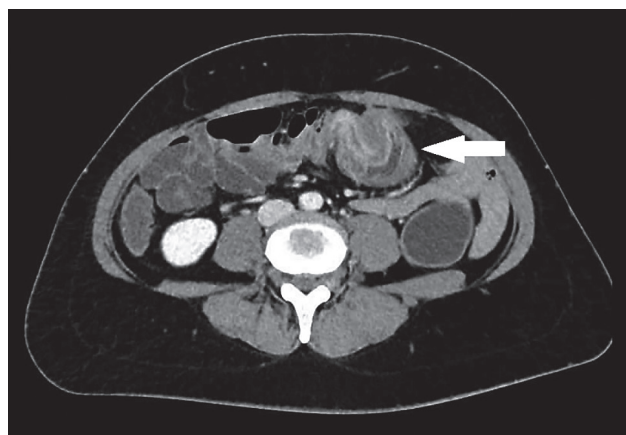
Abdominal hydro-computed tomography, venous phase, axial view. The “bowel-within-bowel” configuration of transversal colon, in which the layers of the bowel are duplicated forming concentric rings.
